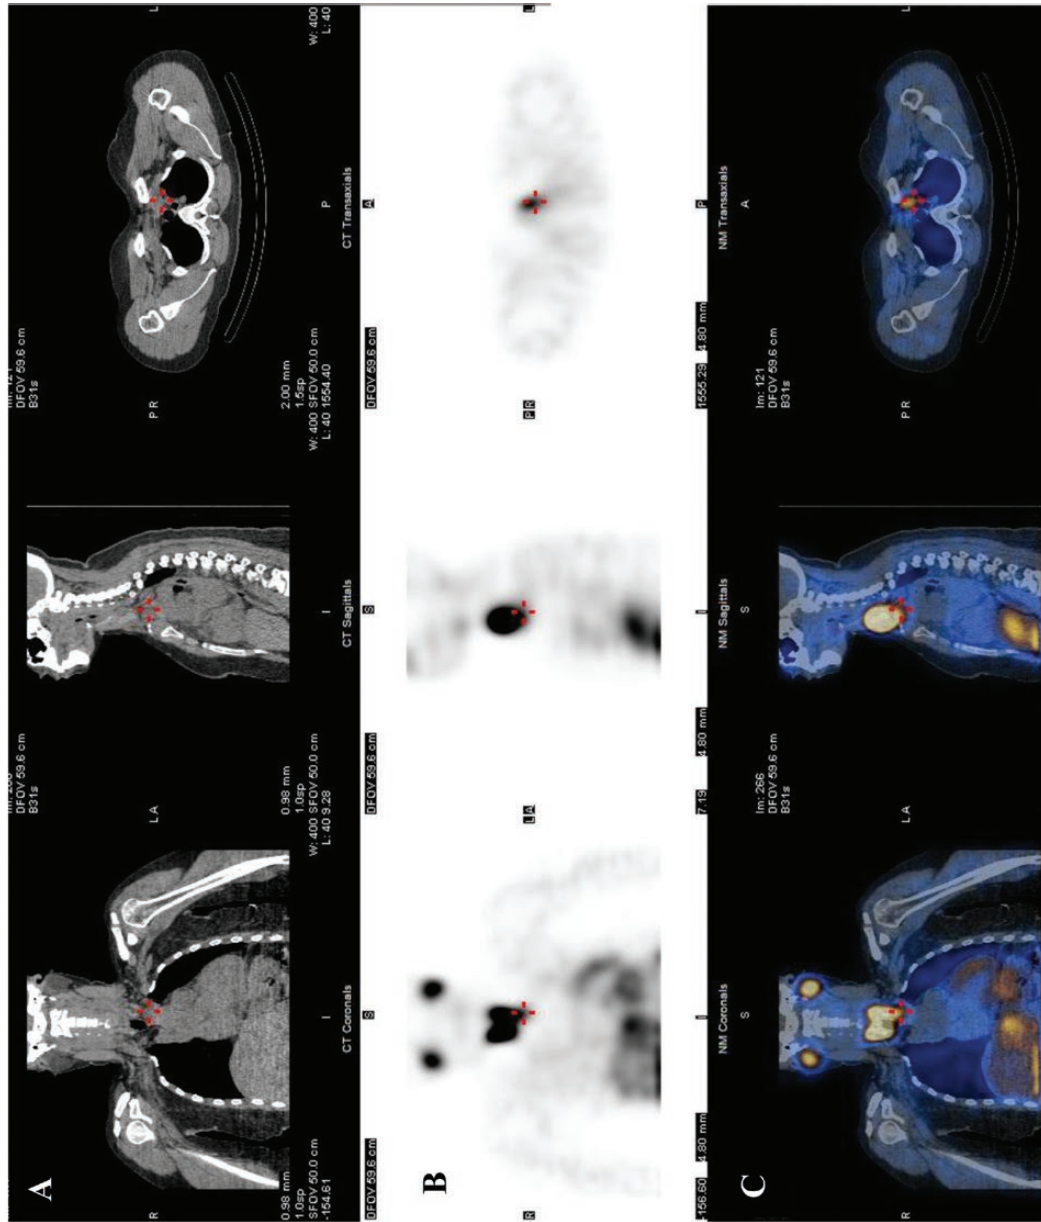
Case 2 ¹²³I-MIBG scan. A: CT for localization and attenuation correction. B: SPECT images. C: Fused SPECT/CT images localizing the lesion to the lower pole of the left thyroid lobe.
